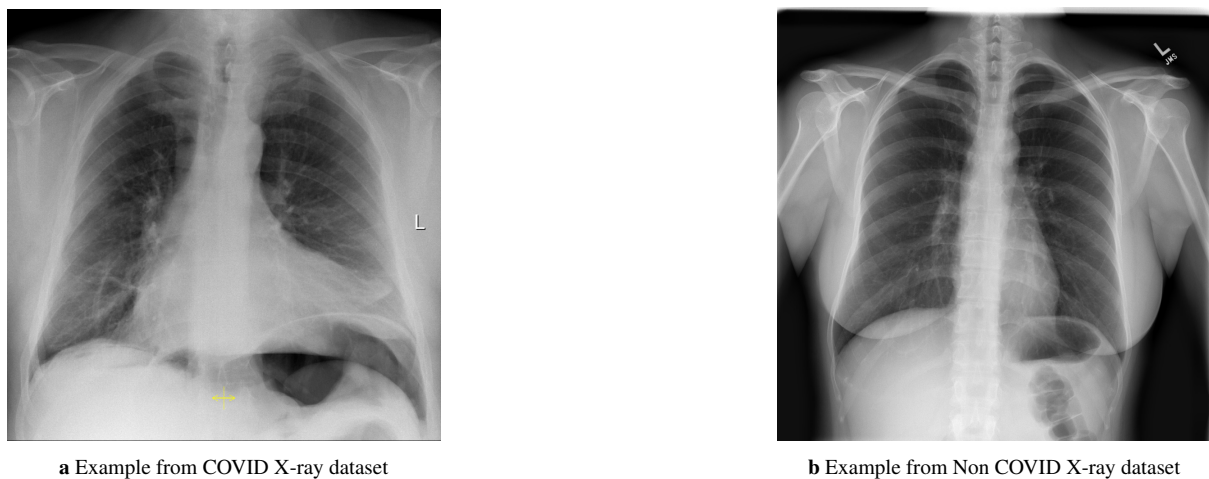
Examples from X-ray dataset [10]
